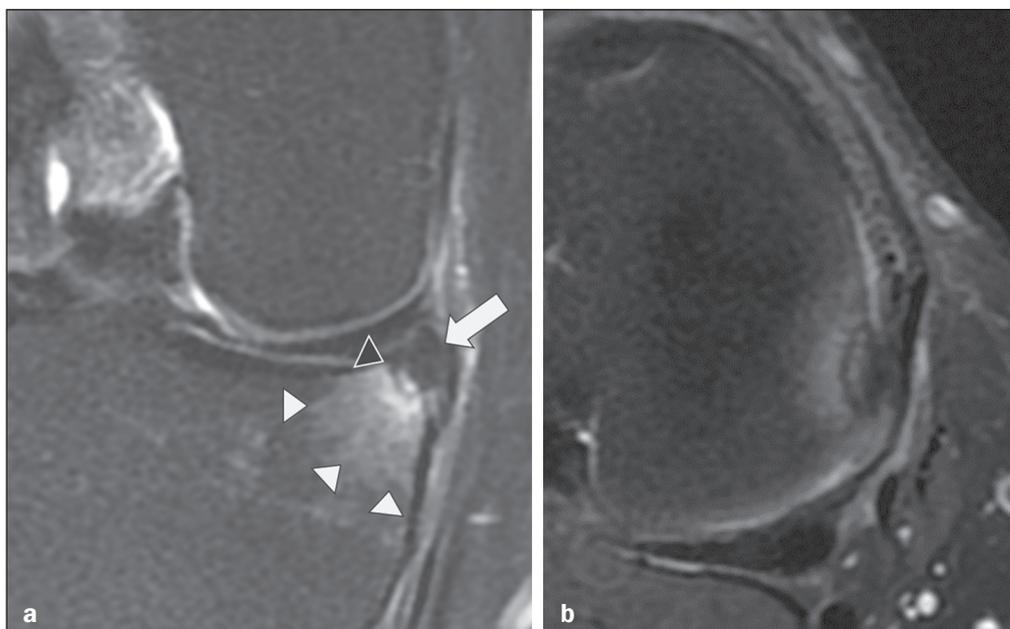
Typical findings of inferior displacement of a meniscal flap tear. T2-weighted MRI with fat saturation in the coronal and axial planes (a and b, respectively), showing a meniscal lesion with a flap (arrow) displaced into the meniscotibial recess, as well as an area of tibial edema (white arrowheads) next to the flap. In this case, adjacent bone remodeling (black arrowhead) can also be observed.
